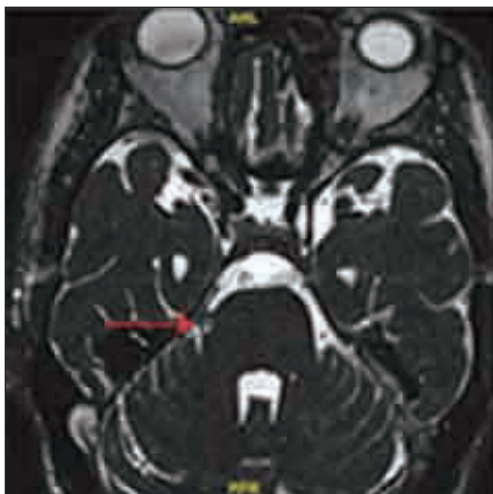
Brain MRI and an intraoperative photograph showing that a Teflon granuloma (arrowhead) compressed the right trigeminal nerve.
